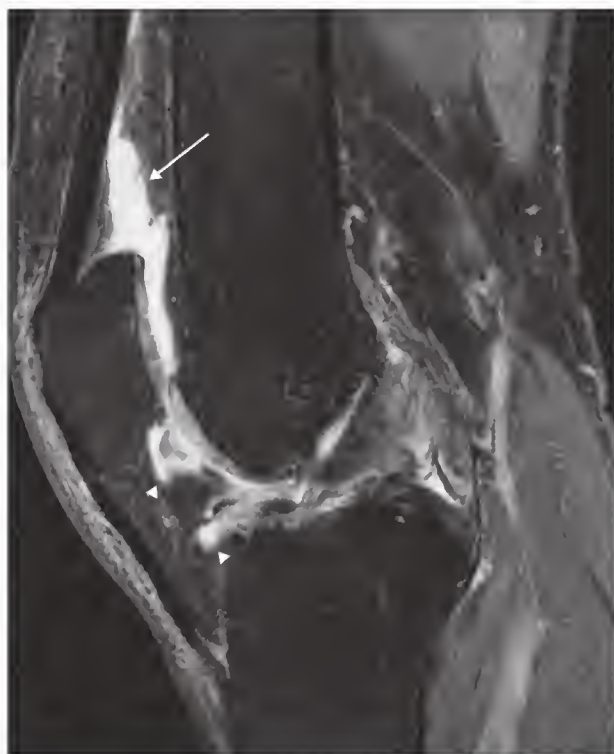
Sagittal fat-suppressed intermediate-weighted magnetic resonance image showing knee joint effusion (arrow) and infrapatellar synovitis (arrowheads). On this non-contrast-enhanced image the magnitude of synovitis is difficult to determine.
